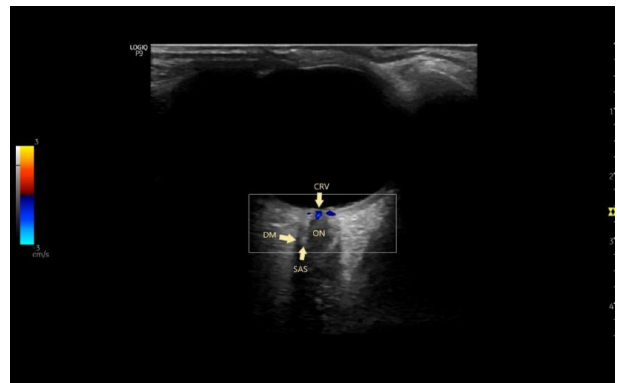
The hypoechogenic optic nerve (ON) emerges from the hyperechogenic optic disc. It is surrounded by the hyperechogenic subarachnoid space (SAS) and the hypoechogenic dura mater (DM). The peri-orbital fat is hyperechogenic. The central retinal artery (CRA) is identified with the Doppler function. It is situated in the center of the ON.
